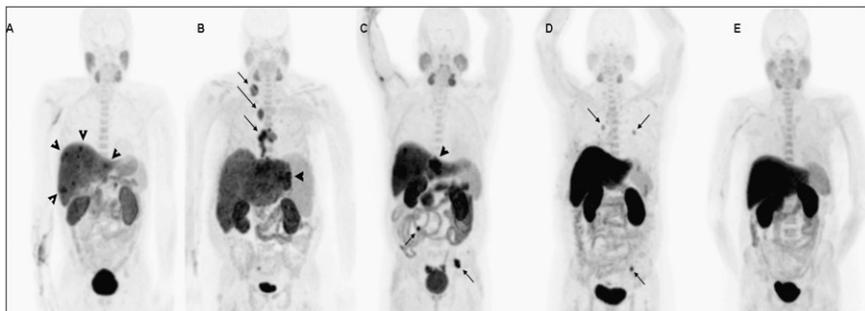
^{18}F -fluorocholine PET/CT assessment of hepatocellular carcinoma (HCC) and remnant liver function. Despite high background activity, HCC could still be discriminated on the basis of tumor uptake.
